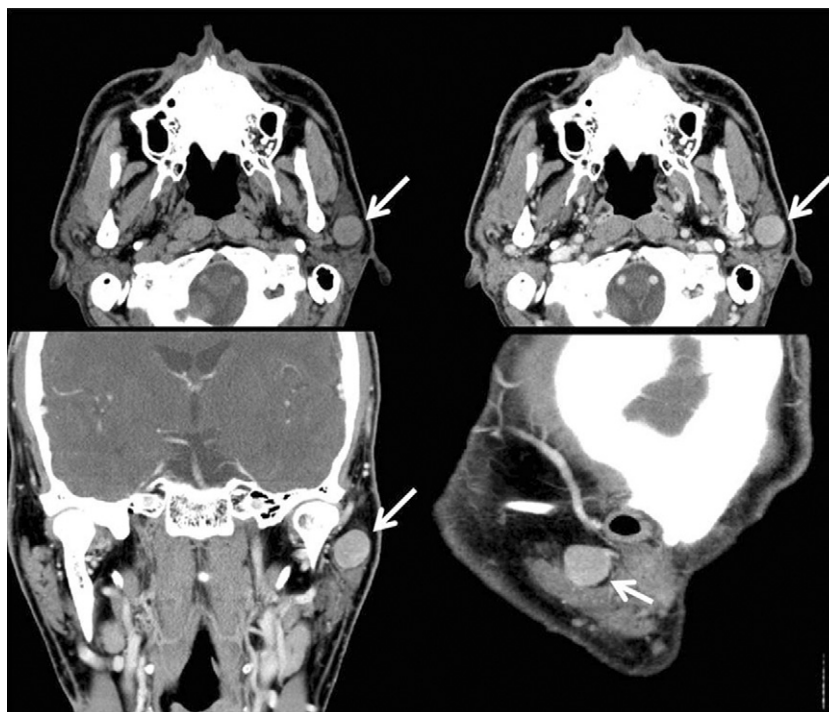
Preoperative neck computed tomography (CT) scan a 1.6 cm sized round and well defined enhancing nodular lesion in superficial lobe of the left parotid gland (white arrow).
